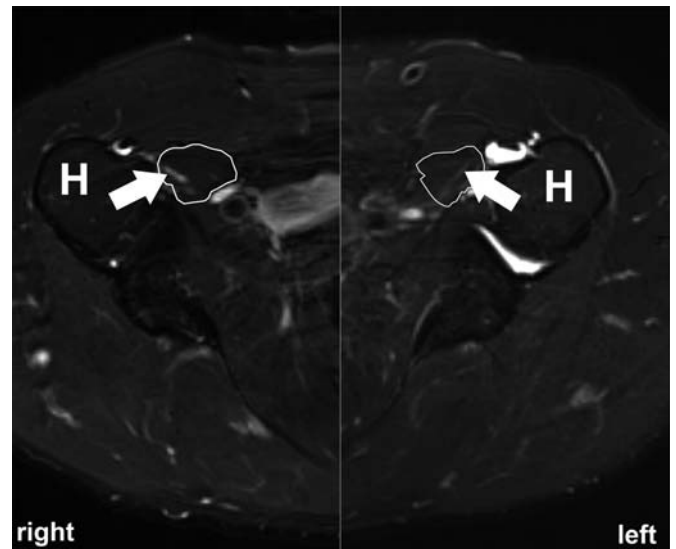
A 58-year-old patient 6 years after Oberlin's transfer. The transfer was performed to treat complete musculocutaneous nerve injury after shoulder arthroscopy for rotatory cuff reconstruction. Axial fat-suppressed T2-weighted MR image of the normal left and operated right side shows persistent thickening of the right musculocutaneous nerve (arrow) as well as neurogenic edema with increased T2 signal intensity proximal to the anastomosis at the level where the nerves course within the short head of the biceps muscle (encircled). The absence of neurogenic muscle edema or biceps atrophy is indicative of a functional recovery. The clinical findings (biceps M5, DASH score, 18) correlated with the MR imaging of the muscle. H, humeral head.
